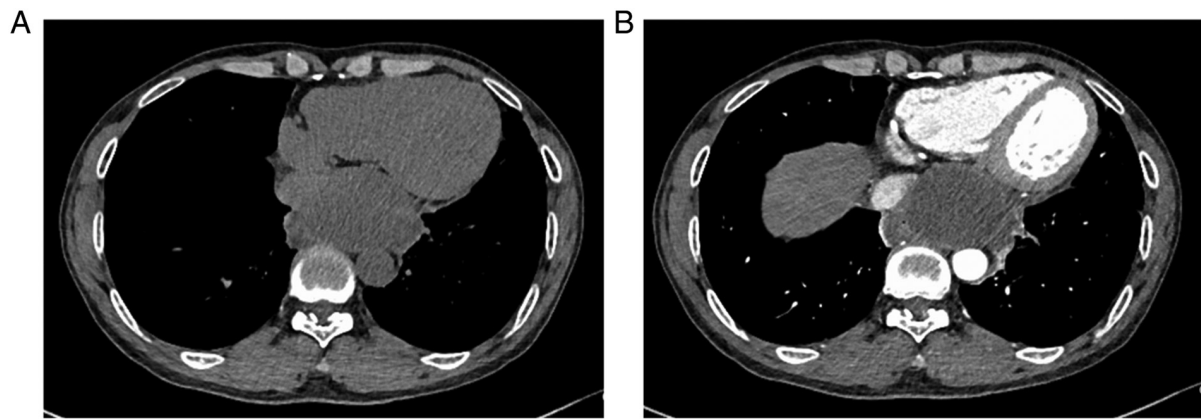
Thoracic computed tomography images of mediastinal cyst. (A) Plain CT image. (B) Enhanced CT image. CT, computed tomography.
